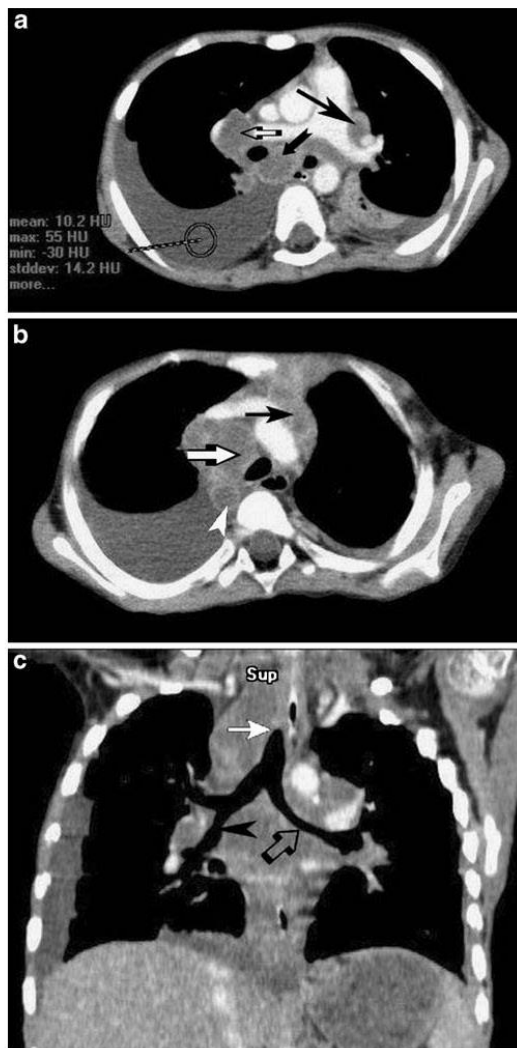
Case 1: CT of the thorax in a 35-month-old boy. a A large right-sided pleural effusion (10.2 HU) and a small left-sided effusion are demonstrated. The patient has extensive mediastinal lymphadenopathy: subcarinal (*short black arrow*), right hilar (*open arrow*) and aortopulmonary window (*long black arrow*) nodes are visible. The nodes demonstrate central necrosis with rim enhancement, typically found in tuberculous lymphadenopathy. Thoracic duct compression is likely. b There is extensive right paratracheal lymphadenopathy (*white arrow*) with compression on the trachea. Nodes are also present in the aortopulmonary window (*black arrow*). The nodes demonstrate ghost-like (*white arrow*) and ring (*white arrowhead*) enhancement. Large right-sided and smaller left-sided effusions are visible. c Coronal reconstruction demonstrates the large right-sided and smaller left-sided pleural effusions. Extensive mediastinal and bilateral hilar lymphadenopathy demonstrating ghost-like and ring enhancement patterns is visible. There is compression of the distal trachea (*white arrow*), left main bronchus (*open arrow*) and bronchus intermedius (*arrowhead*)
